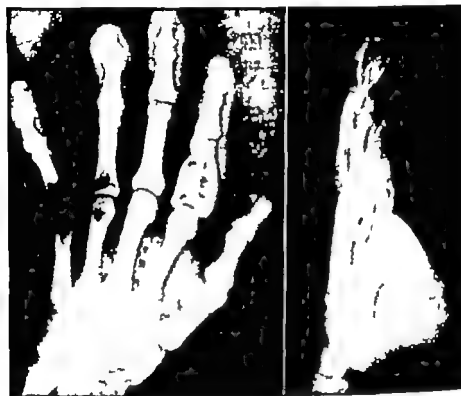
(Courtesy of Deranbeum, S. L., and Traouranis, G. *Am. J. Roentgenol.* 80:479-481, September 1958.)
